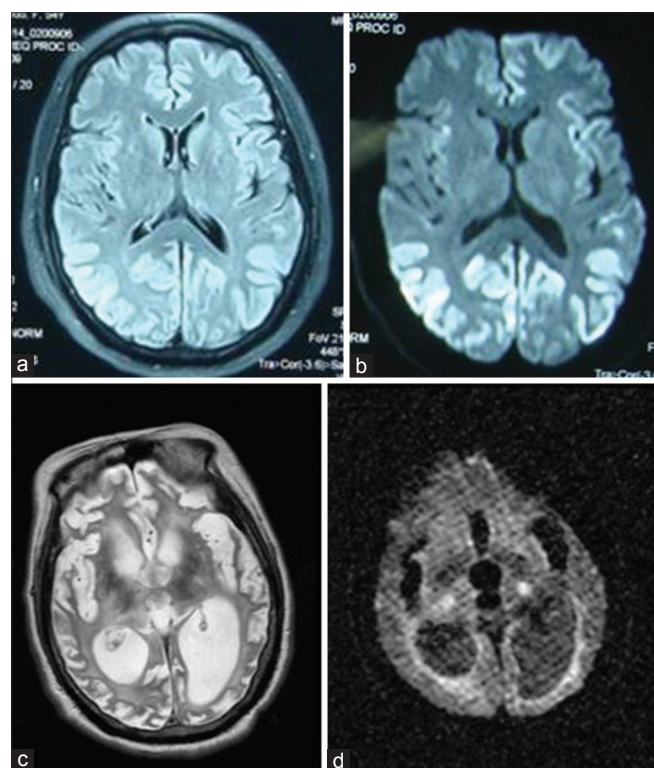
(a and b) MRI representations of a sporadic Creutzfeldt–Jakob disease patient: high signal on both fluid-attenuated inversion recovery image and diffusion-weighted imaging (DWI) (2009–6–16). (c and d) T2-weighted image and DWI image of the same patient in a persistent vegetative state (2011–7–13): serious encephalatrophy with an obvious increase in ventricular volume
